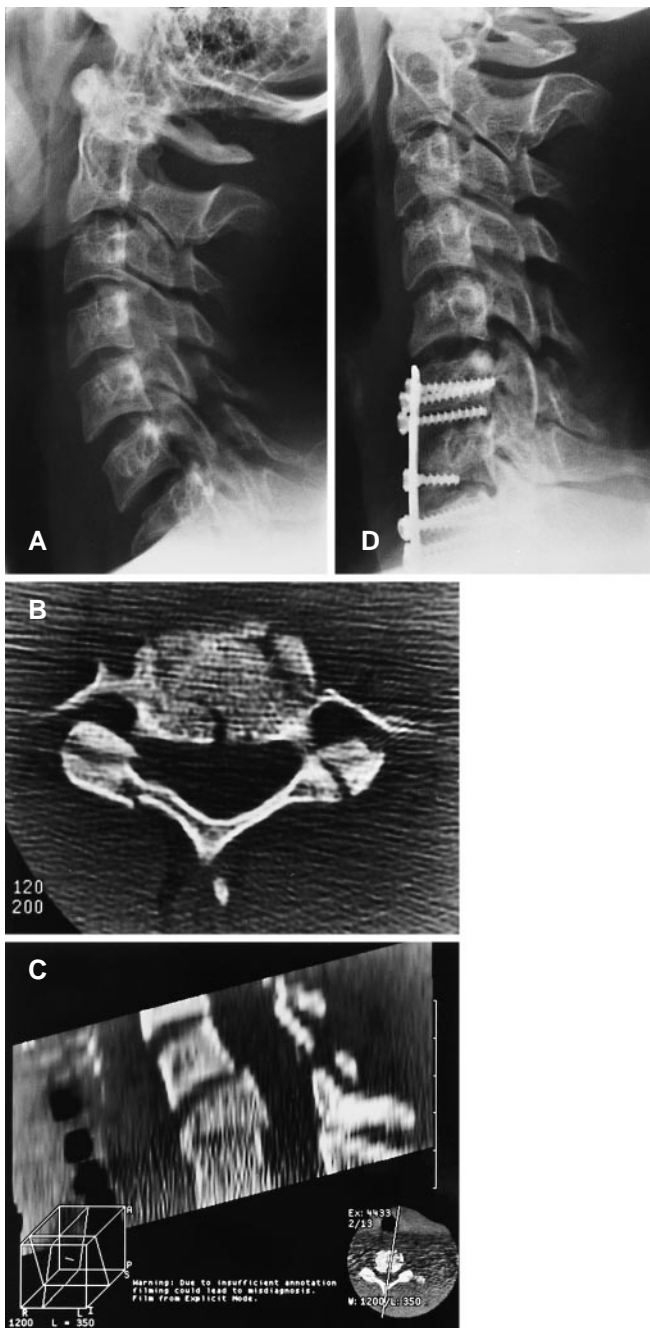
A–D A 21-year-old man sustained a C7 burst fracture in an automobile accident. He had a total loss of motor and sensory functions below the injured level (Frankel grade A). A–C On admission, the radiological examination revealed a C7 burst fracture and retropulsion of bony fragments into the spinal canal. The patient underwent an anterior decompression and Caspar plate fixation. On the follow-up 11 months later, the patient was capable of moving by wheelchair and had limited motor functioning in the lower extremities (Frankel grade C). D The lateral radiograph showed preservation of the alignment and no kyphotic deformity
